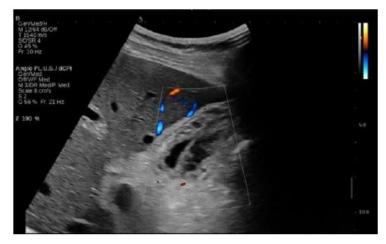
Doppler US shows no vascularization present in the intraluminal hyperechoic structure in gallbladder.
